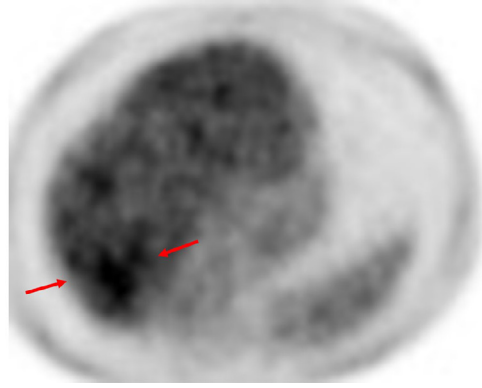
PET-CT scan shows ^{18}F -FDG uptake in the VII liver segment corresponding to the CT lesion.
